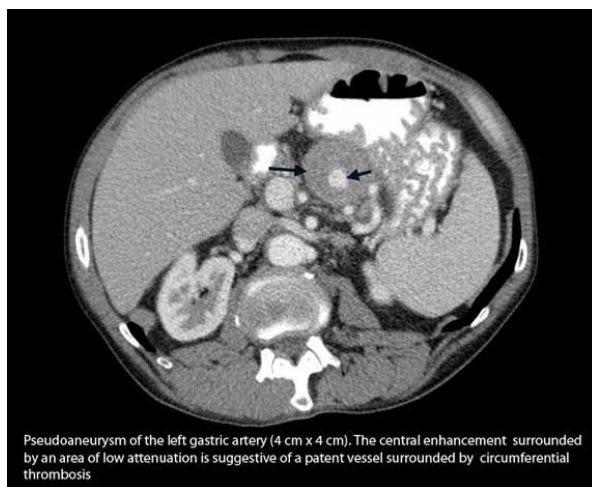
Computed tomography scan of the abdomen demonstrating pseudoaneurysm of the left gastric artery, measuring 4 cm x 4 cm, with circumferential thrombosis
